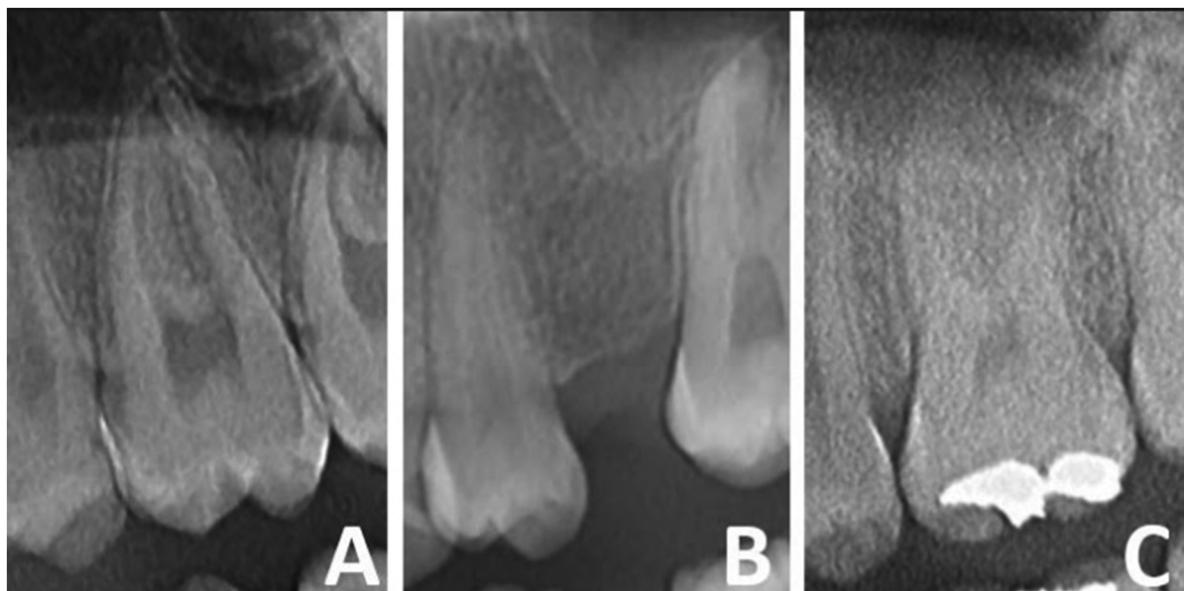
Radiographic representation of unrestored (A; coded as “H”), missing (B; coded as “X”), and filled (C; coded as “R”) teeth.
